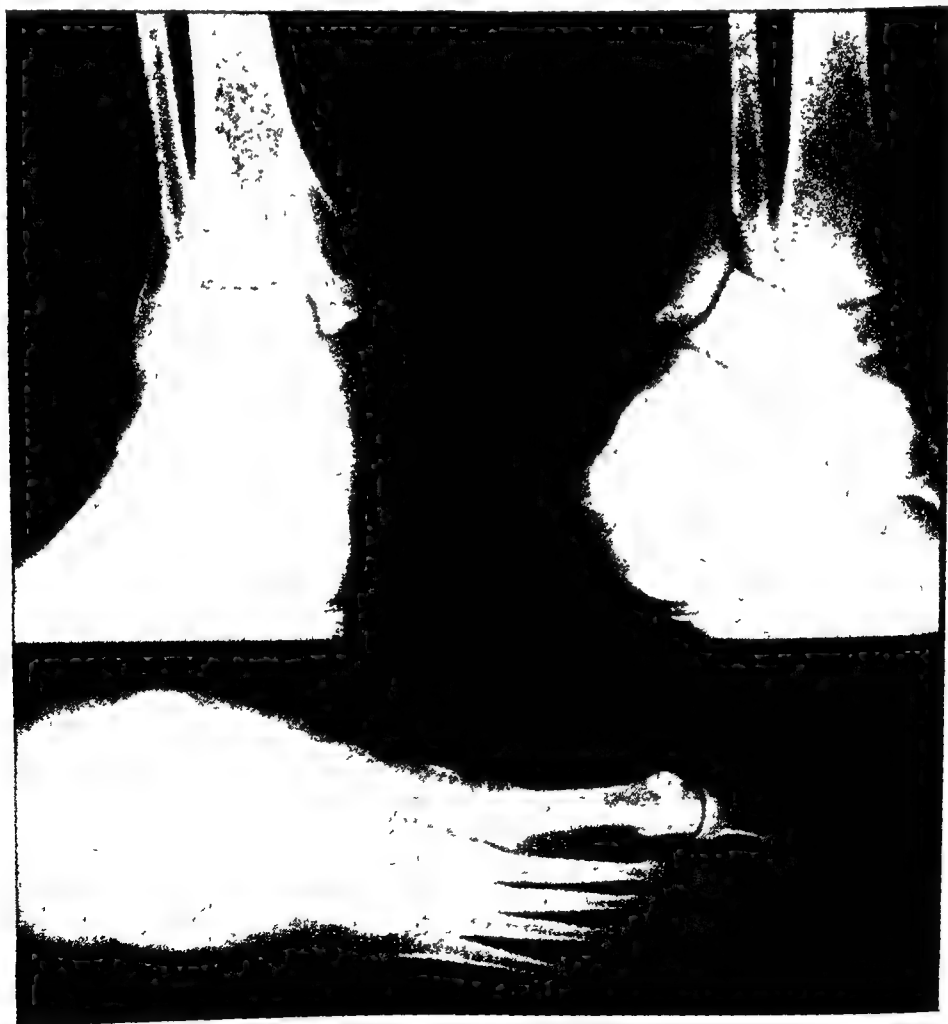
EMERGENCY ROENTGEN EXAMINATION—FRACTURE.
